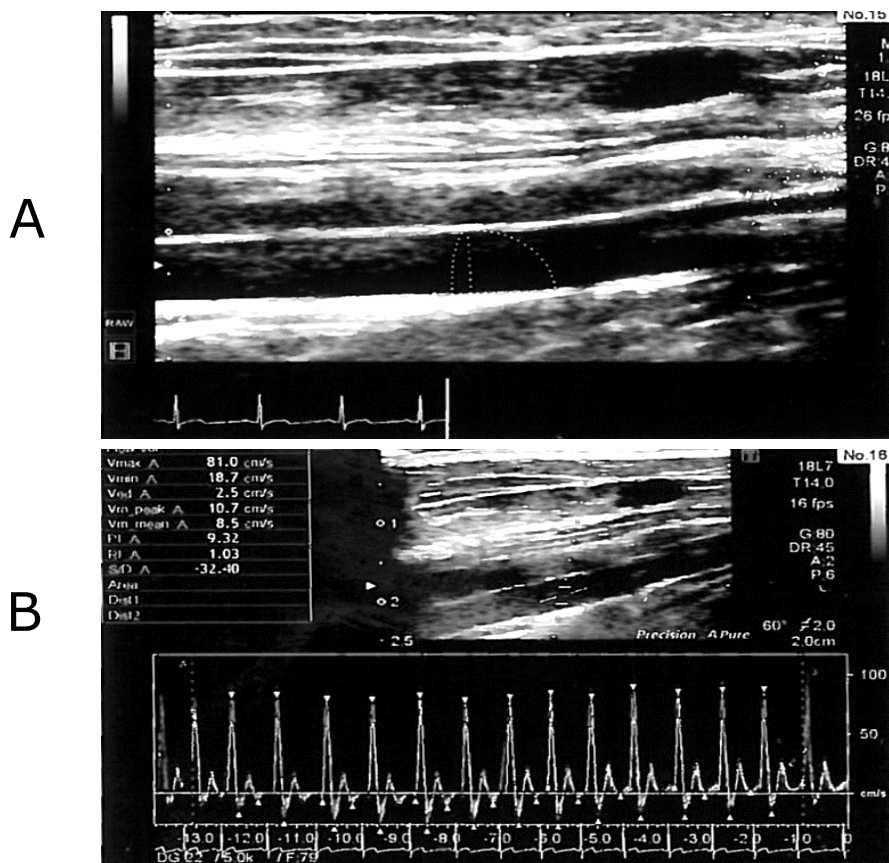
Ultrasound image from the determination of brachial artery diameter (A) and flow velocity (B) in a representative subject.
